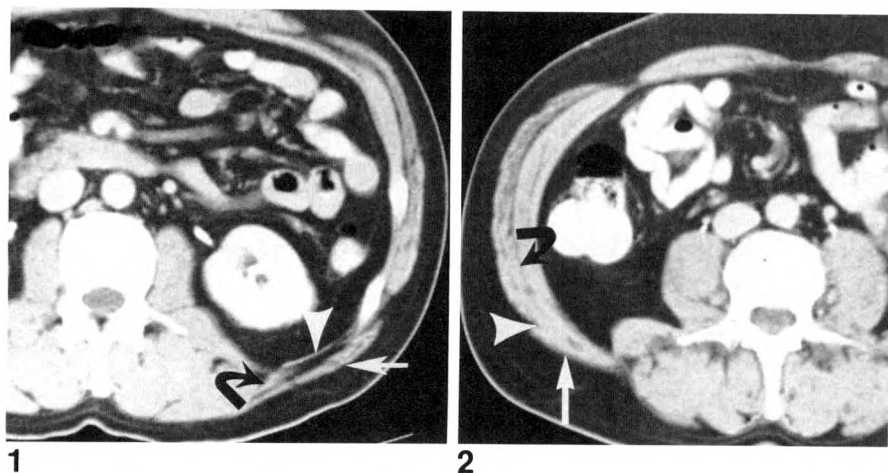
CT through base of superior lumbar triangle in normal patient showing latissimus dorsi muscle (arrow), serratus posterior inferior muscle (curved arrow), and thoracolumbar fascia (arrowhead).
